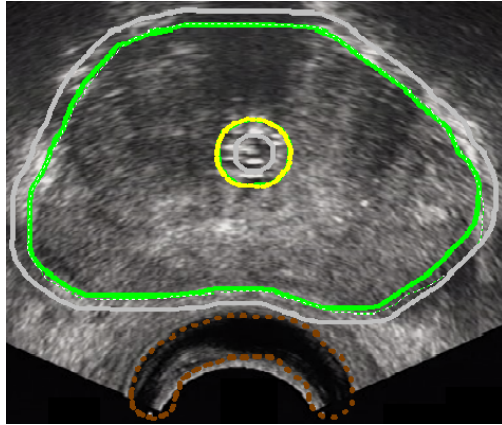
A transrectal ultrasound image with delineated target volume (green) extended with an isotropic margin (gray), rectum (brown) and urethra (yellow). The gray delineation is a safety margin accounting for uncertainties, see Section 1.1.1.
